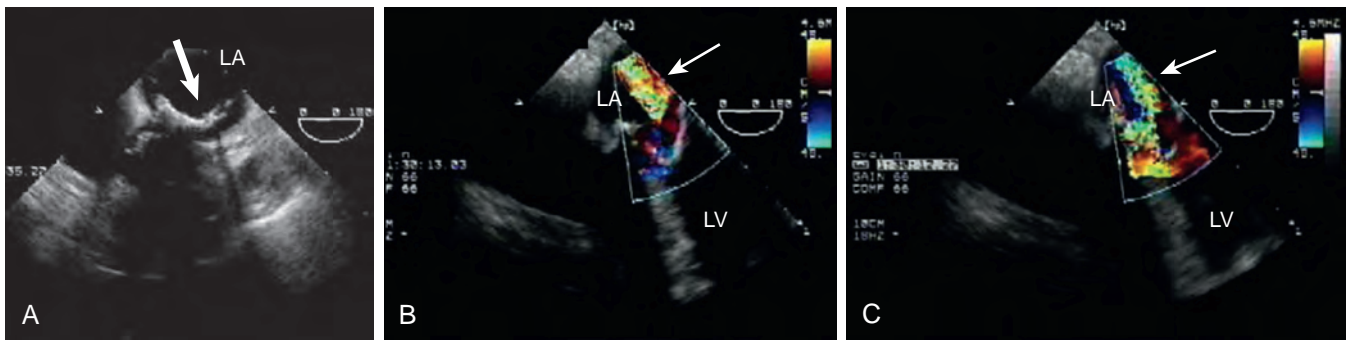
Bioprosthetic valve dehiscence along the posterior mitral annulus. (A) Echo clear (arrow) space below the annular prosthesis with advancement of the transesophageal echocardiography probe. (B) and (C) Associated severe mitral regurgitation (white arrow). LA, Left atrium; LV, left ventricle.
